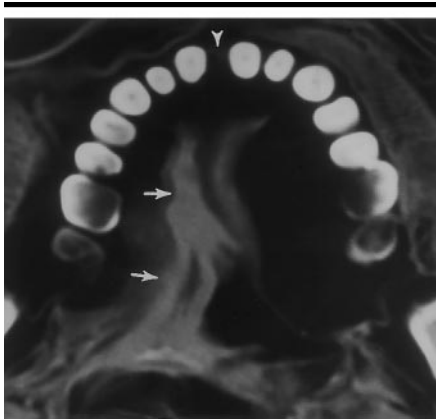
Transverse CT section through the maxillary teeth (obtained on September 25, 1991) shows 14 teeth and bilaterally absent third molars. Note the diastema (arrowhead) and the dehydrated tongue (arrows).
